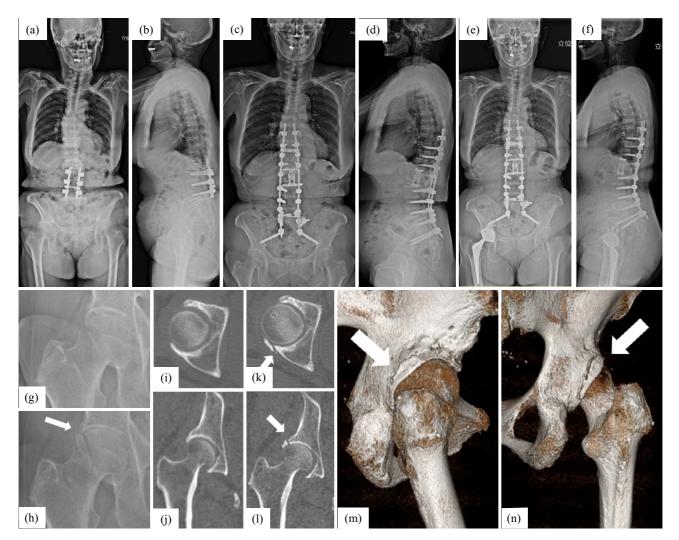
Case 1. Standing radiograph reveals the change in thoracolumbar alignment before (a, b) and after (c, d) adult spinal deformity surgery and total hip arthroplasty (e, f). Standing X-ray imaging shows the hip joint without osteoarthritis 1 month after adult spinal deformity surgery (g), but acetabular rim fracture and progression of hip osteoarthritis occurred 4 months later (h). The acetabular rim was not fractured before spinal long fusion surgery (i, j) but fractured at 4 months after adult spinal deformity surgery on computed tomography (k, l) and three-dimensional images (m, n).
